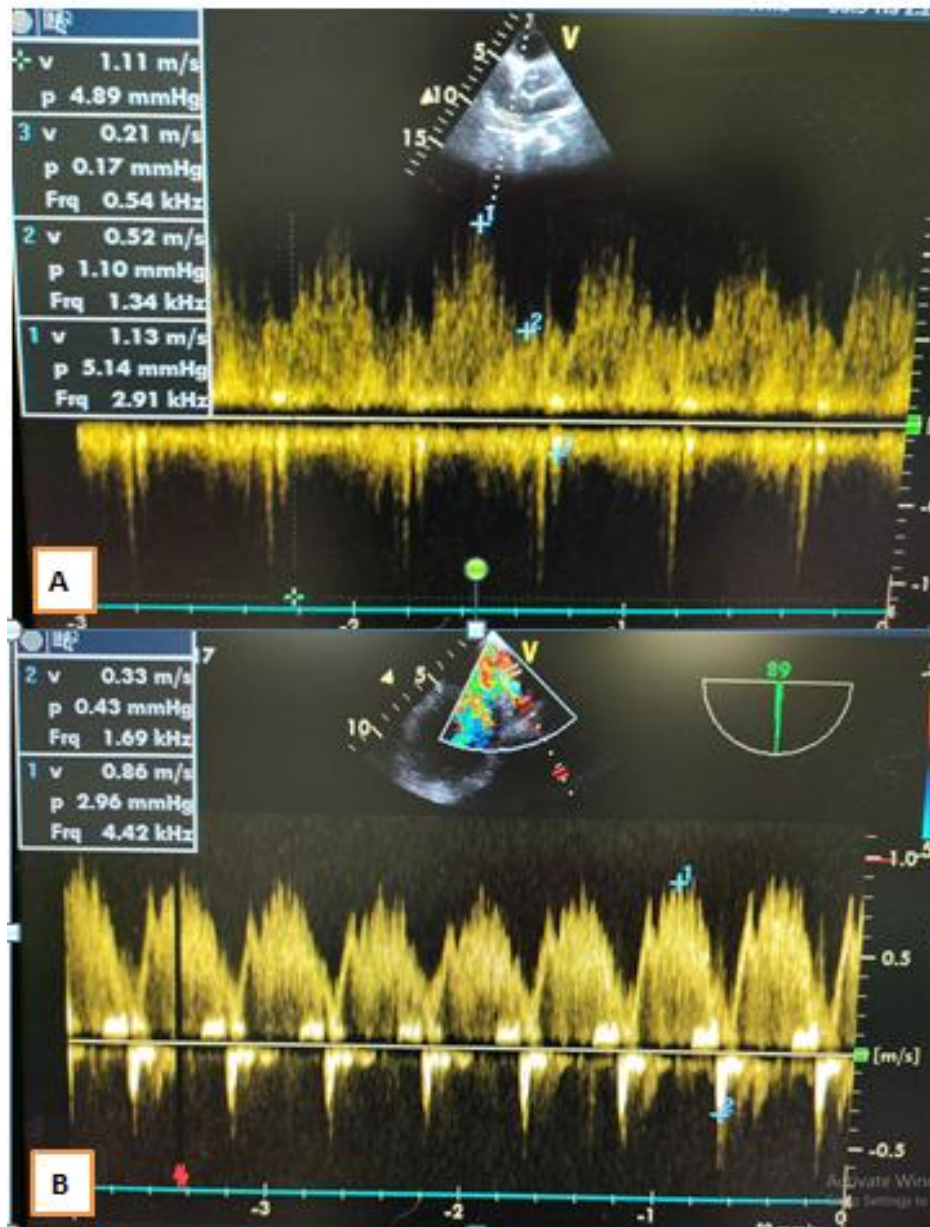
Pulmonary venous flow pattern by transthoracic (A) and transesophageal (B) echocardiography of female patient aged 27 years old (70 kg) before ASDII closure showed continuous single antegrade wave with diminished AR wave
